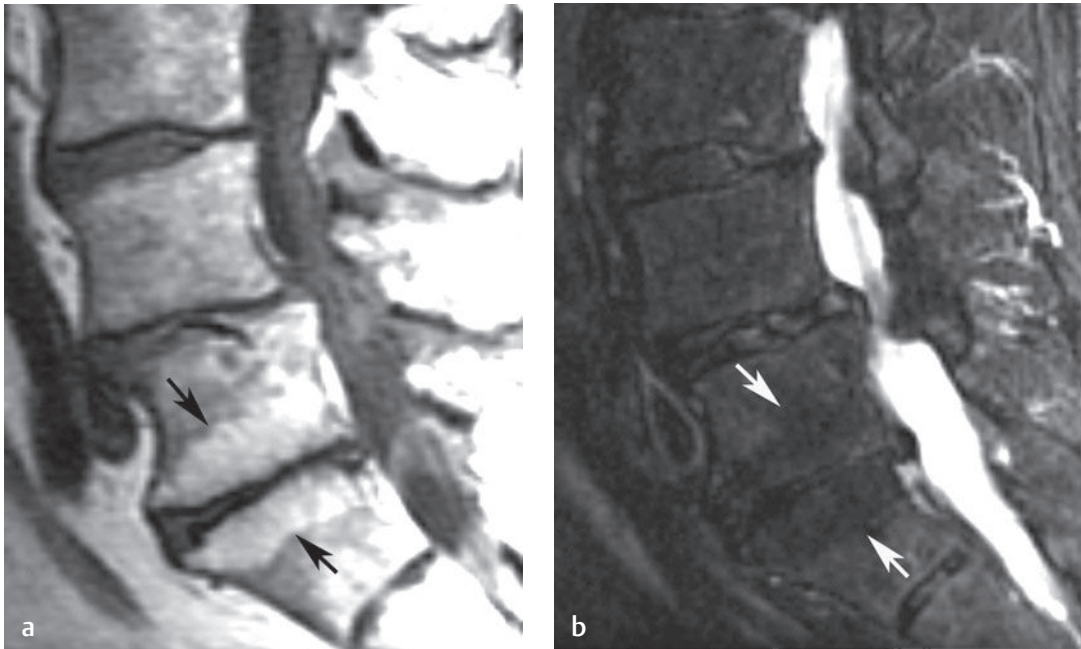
Modic type-2 (fatty) changes. Sagittal (a) T1-weighted and (b) fat-suppressed T2-weighted images show, at the L5-S1 level, the typical pattern (arrows on each) of increased signal intensity on the T1-weighted image and decreased signal on the T2-weighted image that is seen with Modic type-2 end-plate changes. Note that degenerative changes and stenosis are also seen at other levels.[†]
